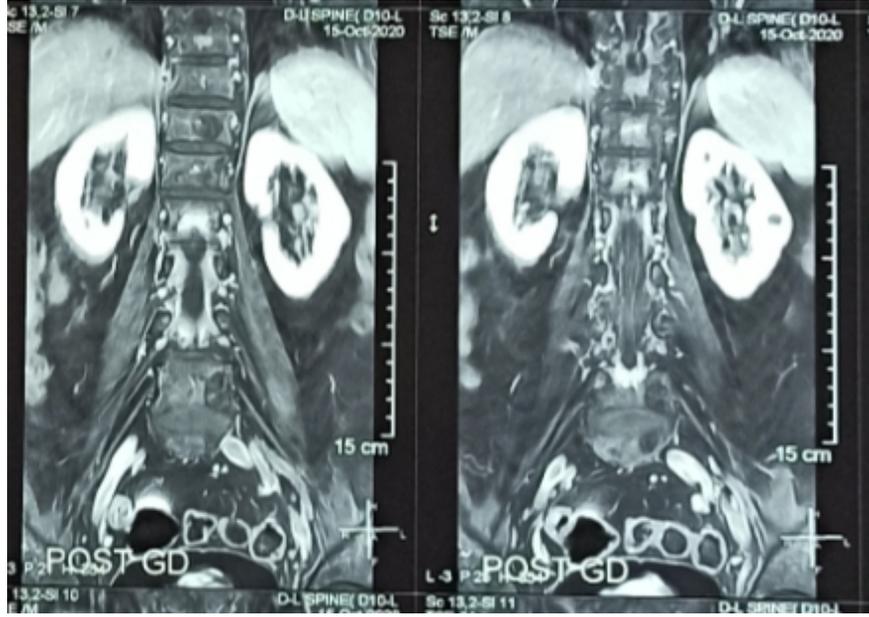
MRI with contrast T2 weighted showing intramedullary mass. (Coronal view)
